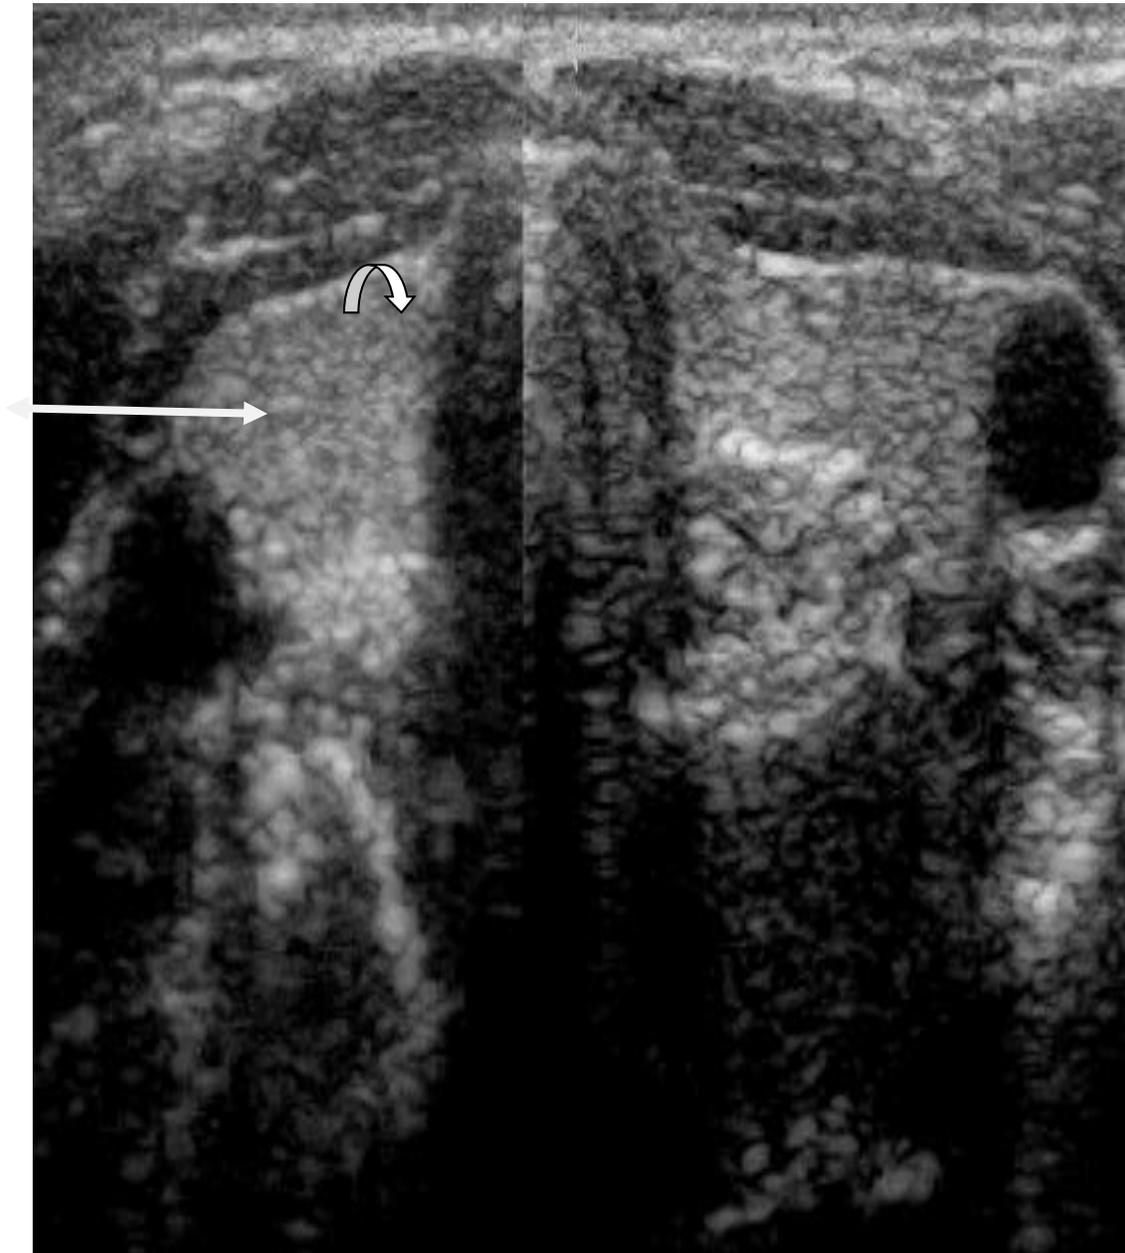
Transverse Ultrasound Scan of the Thyroid Gland at the Level of the Tracheal Cartilage(C6 level) Showing its two lobes (arrows), the isthmus (arrow head) and the trachea centrally (curved arrow).
